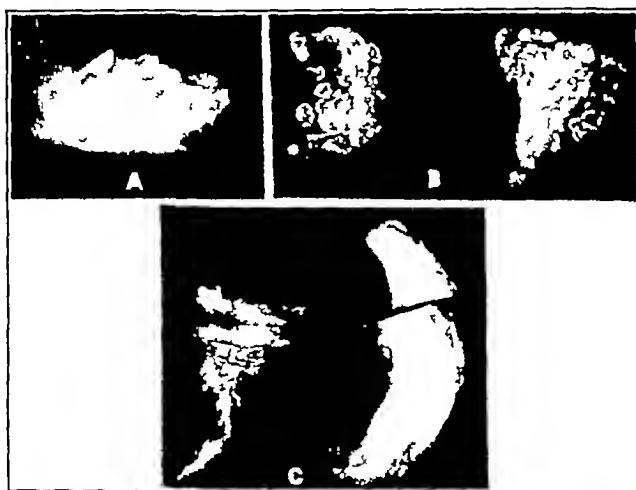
Roentgenograms of calcification in suprarenal taken after removal at post-mortem. A, Case 38. B, Case 39. C, Case 43.
